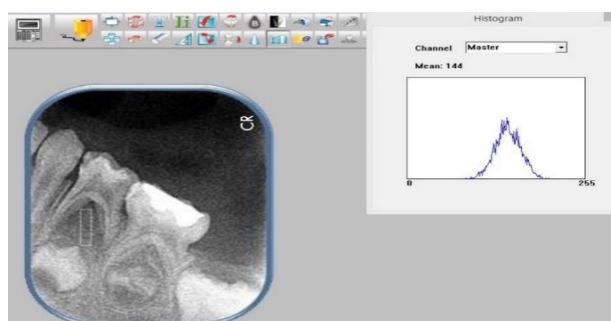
Radiograph imaging is showed measuring of bone density in middle of furcation region showing image software.
